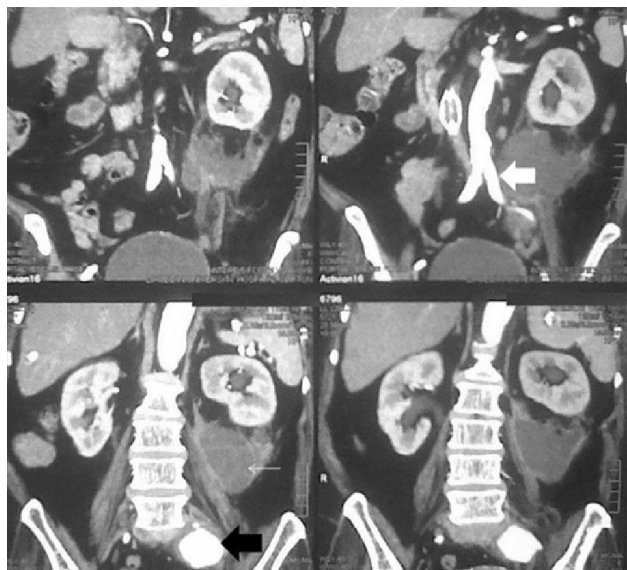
Post Contrast coronal CT images showing pseudoaneurysm from left internal iliac artery (Black arrow). Left common iliac artery (Thick White arrow). Collection (Thin white arrow)
